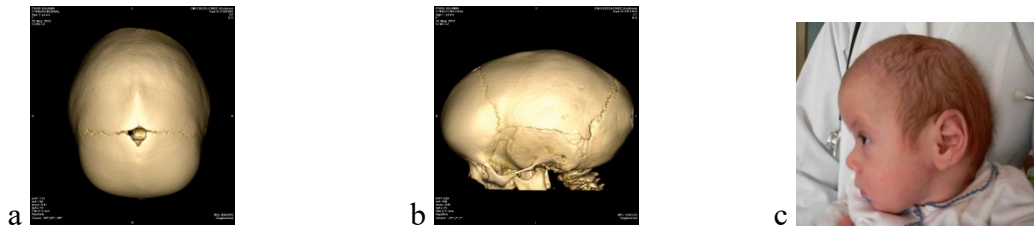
Sagittal craniosynostosis: a, b - CT images (vertical and lateral norm), c - photographic image
